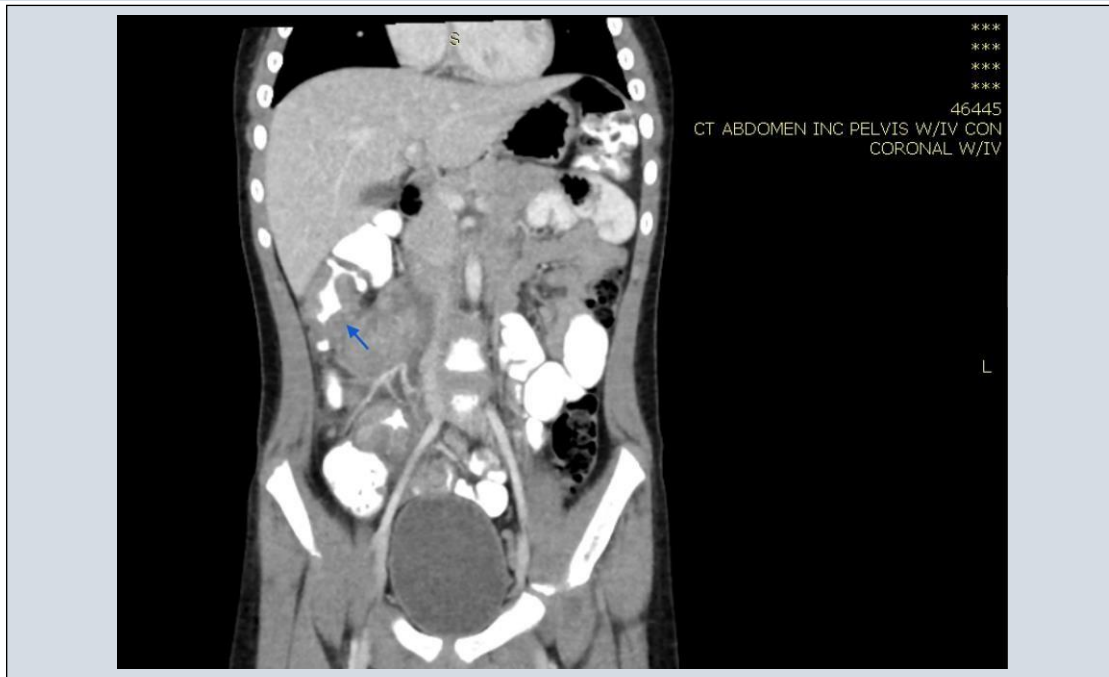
CT abdomen showed focal area of significant wall thickening of the ascending colon is seen and terminal ileum with luminal narrowing (blue arrow), accompanied by multiple variable sized lesions seen in the mesenteric fat of the right side of the abdomen suggestive of enlarged and pathological lymph nodes (the largest measure about 40 X 23 mm) finding suggestive either lymphoma or inflammatory bowel disease(involving the large and small bowel).
